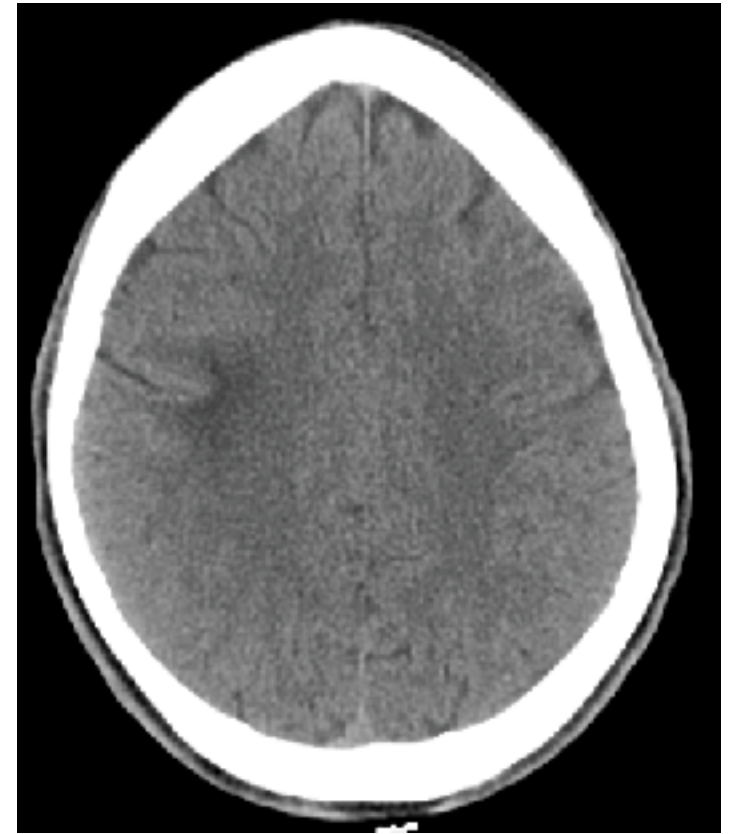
CT Head without contrast: Vasogenic edema in the right frontal lobe, concerning for an infectious or neoplastic lesion.
